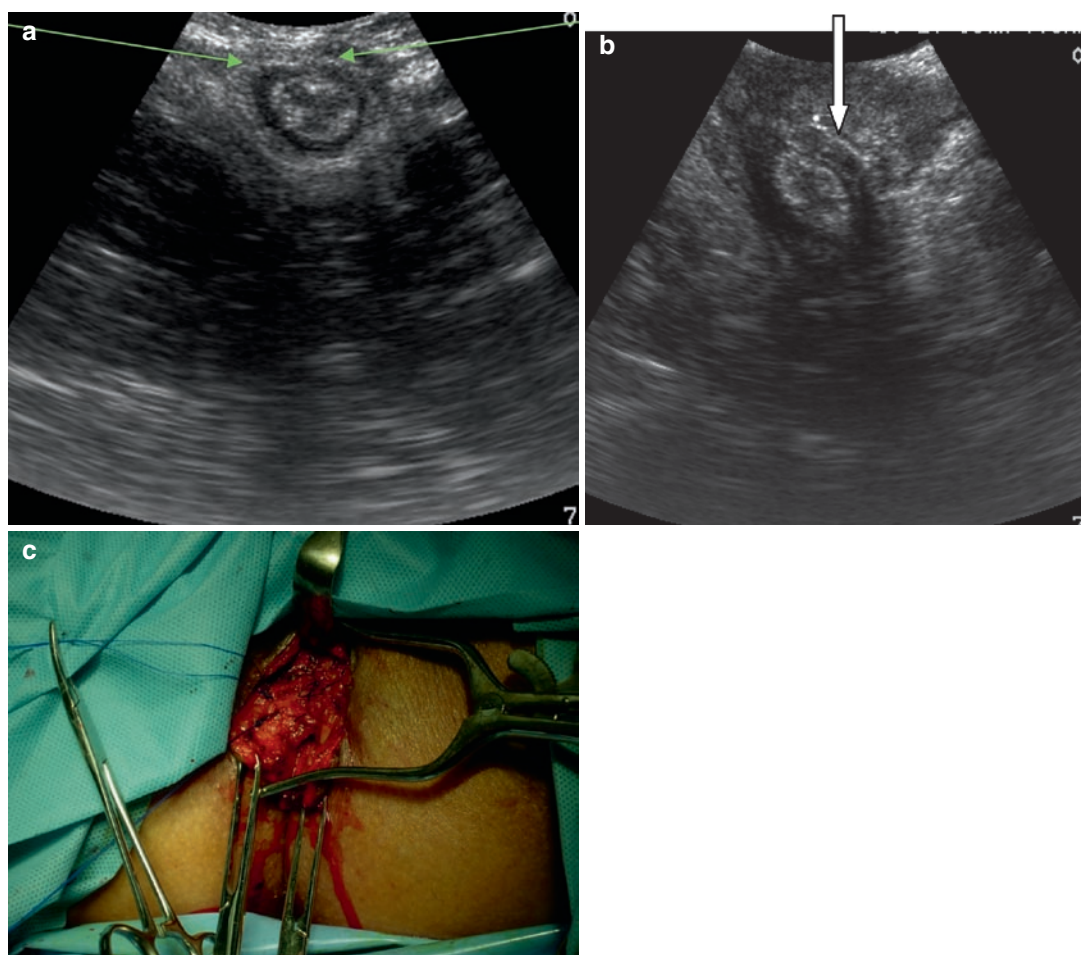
(a) Intraoperative trans-perineal ultrasound of an external anal sphincter defect (arrows), (b) Postoperative trans-perineal ultrasound of overlapping sphincteroplasty at
